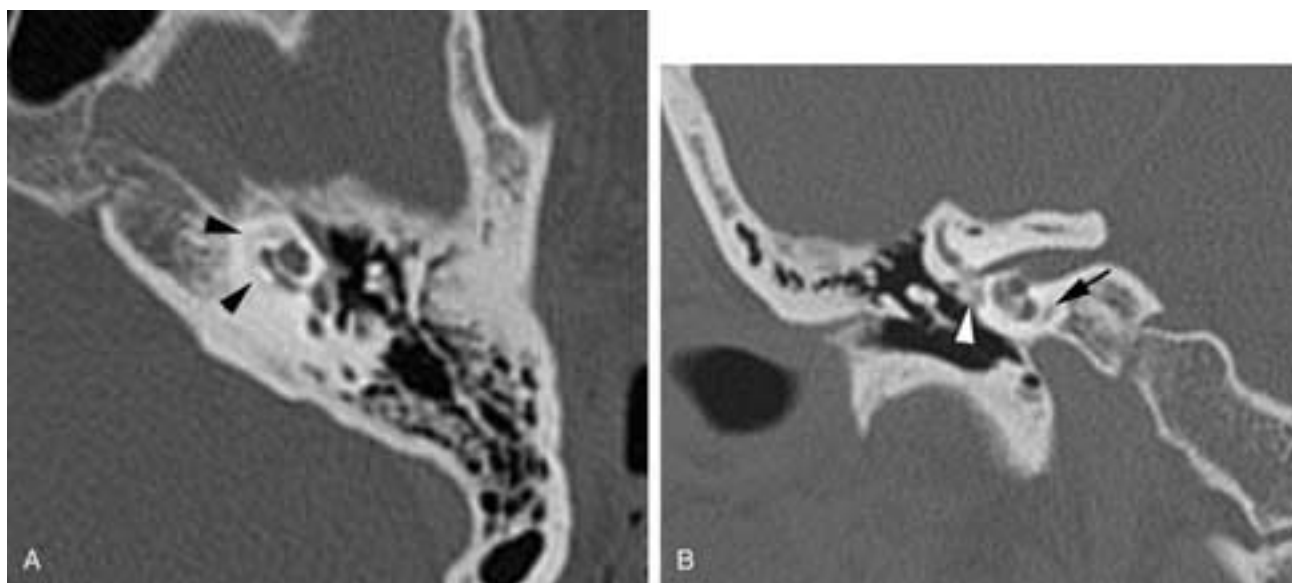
Cochlear (retrofenestral) otosclerosis. A, Axial CT image shows typical demineralization (*black arrowheads*) around the cochlea. Overgrowth of the demineralized, otosclerotic plaque anterior to the oval window is also visible. B, The demineralization of the otic capsule (*black arrow*) and the demineralization just anterior to the oval window (*arrowhead*).
